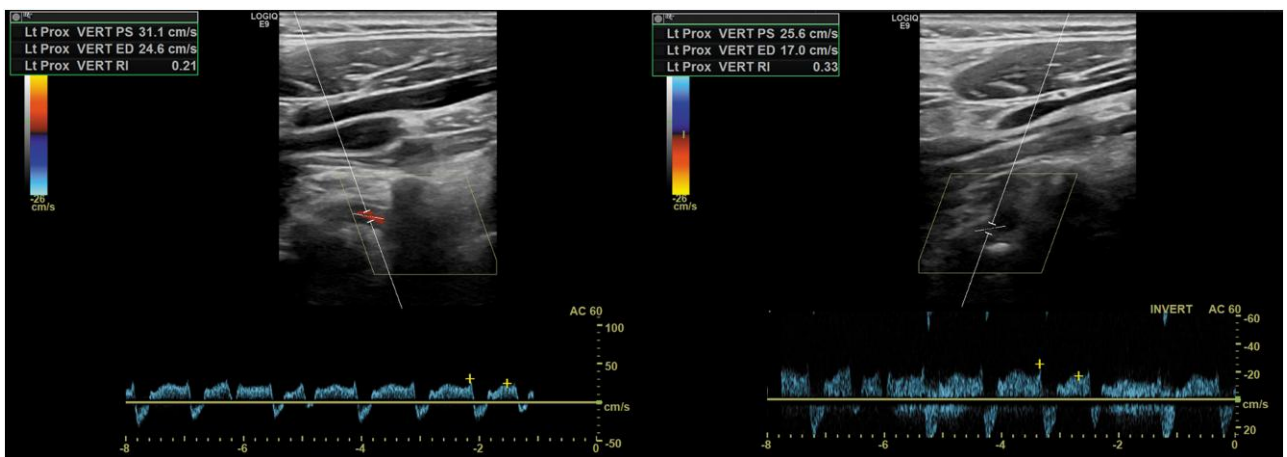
Preoperative Doppler-ultrasound of the left vertebral artery. Flow is inverted during systole.
